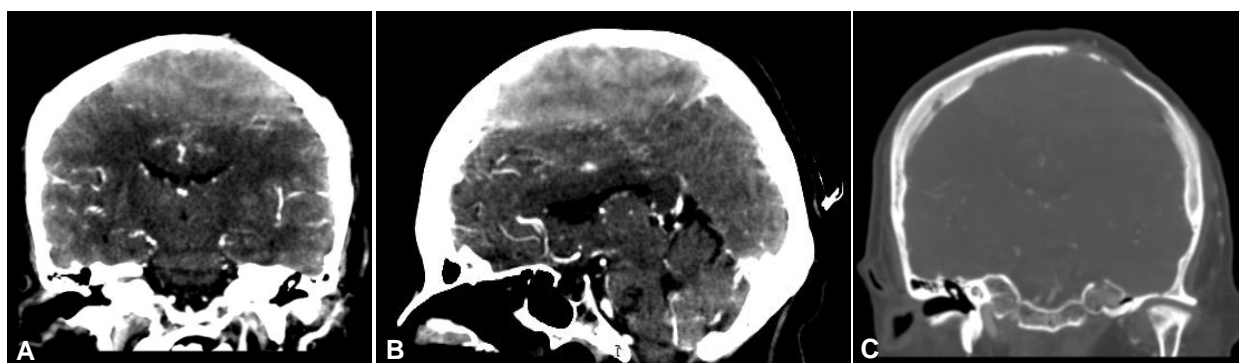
Brain tomography (CT) showing (A, B, C) a bilateral lesion at the frontoparietal level, a contrast-binding agent that erodes the cranial calvaria and causes a mass effect that collapses lateral ventricles.
